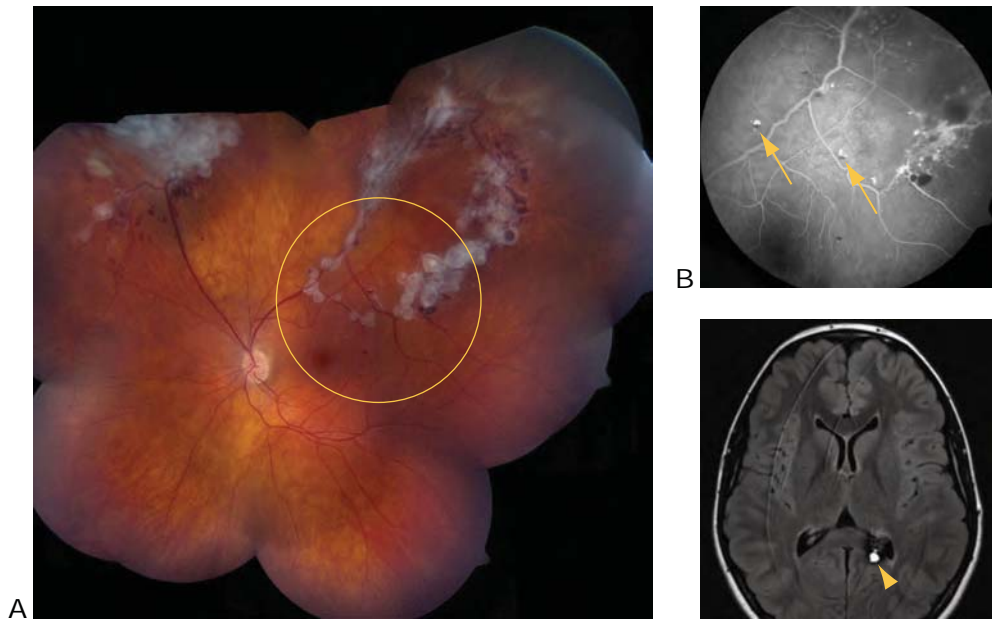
Retinal cavernous hemangioma in a 13-year-old girl. A, Color fundus image montage of the left eye (right eye was normal) shows superficial gliosis and grapelike clusters of thin-walled saccular angiomatous lesions in the inner retina. B, FA (of the area circled in A) shows characteristic findings of dilated saccular lesions and plasma-erythrocyte layering (*arrows*) but no leaking because of stagnant blood flow. C, Magnetic resonance image (T2 fluid-attenuated inversion recovery) demonstrates an associated left-sided cerebral cavernous hemangioma (*arrowhead*). The patient underwent stereotactic image-guided resection to reduce the risk of intracranial hemorrhage. (Courtesy of Kenneth Taubenslag, MD, and Stephen J. Kim, MD.)
